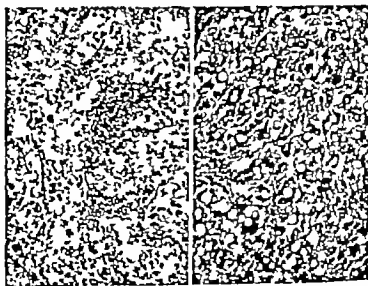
Left, Case 1: Biopsy 8 days after x-ray treatment started (3 days after completion of tumor dose of 3,030 delivered over period of 5 days). There are slight to moderate radiation effects, predominantly nuclear hyperchromatism and to a less extent cytoplasmic vacuolization. $\times 70$.
